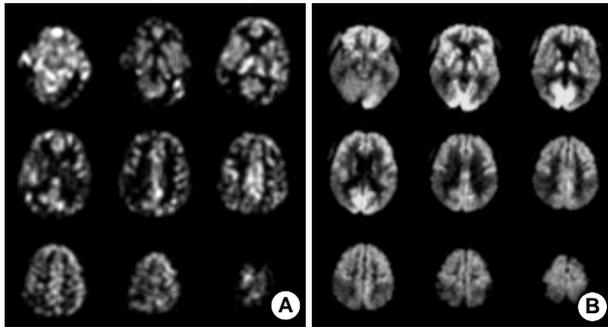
Multislice-CASL image (A) of AD showed characteristic cerebral blood flow decrease in bilateral temporoparietal cortex. Cerebral glucose metabolism is decreased in the corresponding areas in FDG-PET (B) of the same patient.
